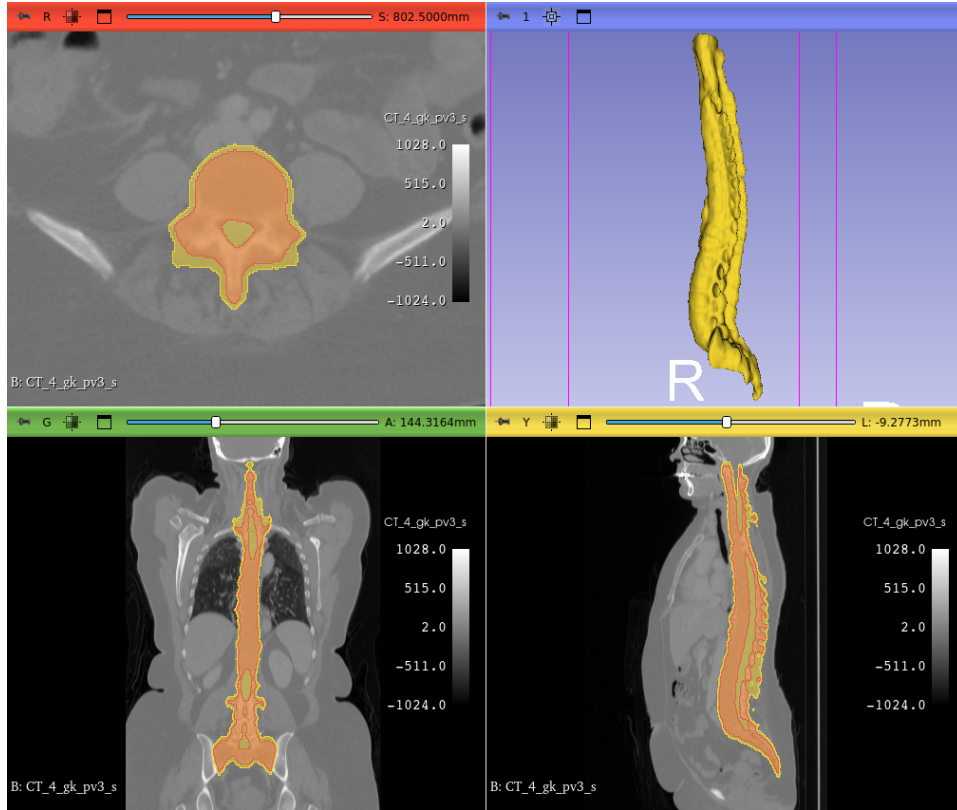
Example of *dilation* process for segmentation shaping. In the image are represented a CT image (black and white) and two spine segmentation: in red is represented the original spine segmentation, and in yellow the spine segmentation after the application of the *dilation* process. All the elements are projected on the three medical imaging planes and on top right a 3D segmentation rendering is shown. Looking the 3D rendering it is possible to notice that just the dilated segmentations is visible due to the fact that the original one is enclosed by it, as it is represented in the three projections. The original image comes from TCIA public dataset, and they are visualized with 3D Slicer software.
